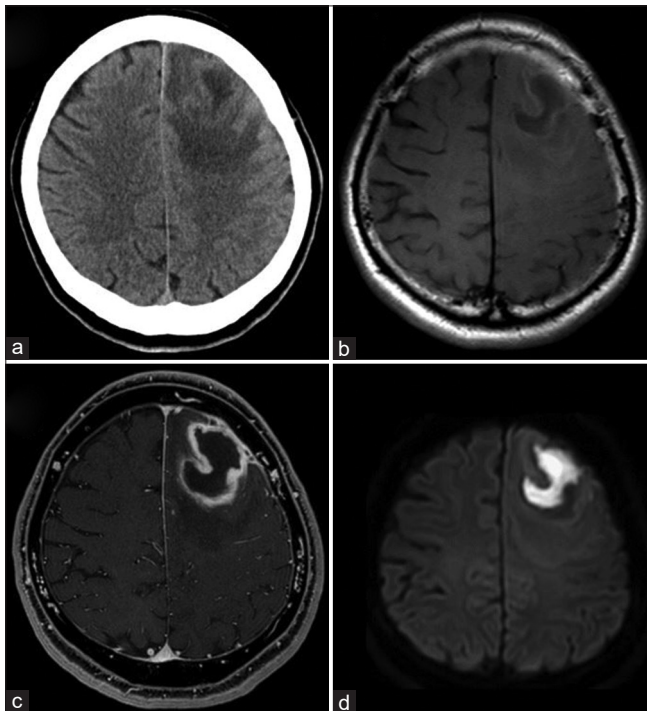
(a) A non-contrast head computed tomography on admission showing a mass lesion with edema in the left frontal lobe. (b) A non-contrast T1-weighted magnetic resonance (MR) image showing a mass lesion in the left frontal lobe. (c) A gadolinium-enhanced MR image showing a ring-enhancement. (d) A diffusion-weighted image (without gadolinium) showing a significant restriction of diffusion in the lesion.
